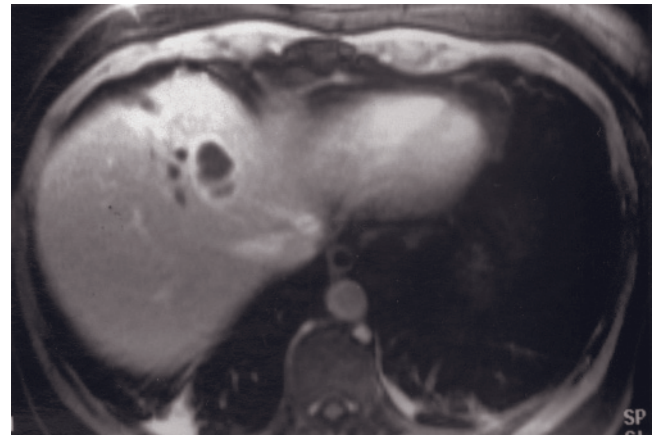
Liver abscesses secondary to infective cholangitis. Coronal (a) and transverse (b) T2-weighted SS-ETSE and T1-weighted immediate (c) and 45-s (d) postgadolinium SGE images. There is a lesion in the right hepatic lobe (arrow, b) that demonstrates increased signal intensity on T2-weighted image (b) and decreased signal on T1-weighted image (not shown). After contrast, the lesion shows a circumferential ill-defined perilesional and capsular enhancement on immediate postgadolinium images (c), with fading of the perilesional enhancement but persistent capsular enhancement on 45-s image (d). There is no enhancement of internal stroma or fill-in of the lesion with time. Note the biliary stent (arrow, a) situated in the common bile duct (a).
